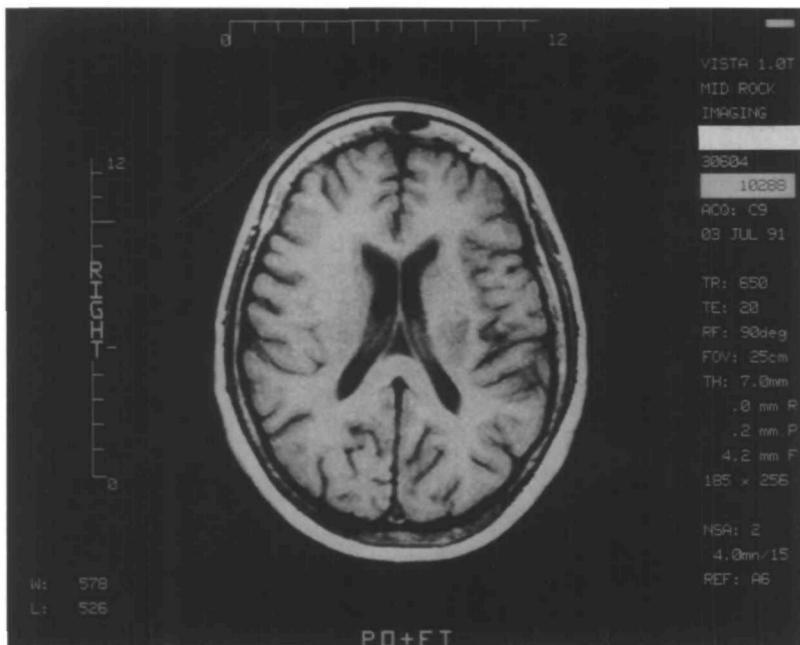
Magnetic resonance image of brain of 65-year-old woman whose speech was characterized by an Irish brogue after subcortical infarction of left hemisphere. Area of increased signal intensity in centrum semi-ovale extends just posterior to waist of left lateral ventricle.
